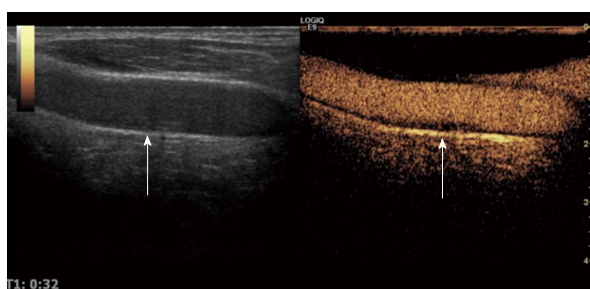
Presence of the vasa vasorum in carotid artery plaque. There are abundant ultrasound contrast agents in carotid artery plaque (arrow).
